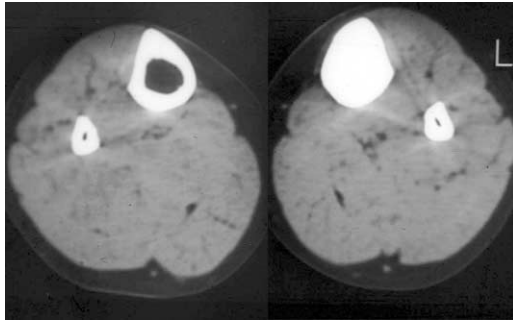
Forty-year-old female patient with pain secondary to chronic osteomyelitis. Axial noncontrast CT scan of the level of the mid tibia demonstrates extensive sclerosis and obliteration of the medullary cavity of left tibia.
